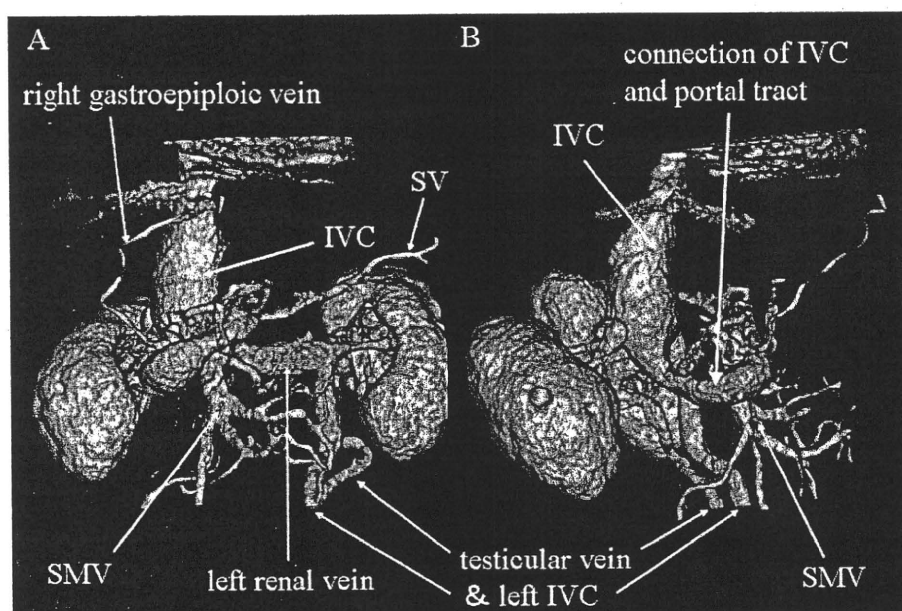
Three-dimensional computed tomography of the venous system. The inferior vena cava (IVC) communicated with the superior mesenteric vein (SMV) and the splenic vein (SV). The IVC disappeared below the level of its connection with the SMV and SV. Two veins, apparently a left IVC and the testicular vein, flowed into the left renal vein. A: Anterior view. B: Right lateral view. IVC: the inferior vena cava, SMV: the superior mesenteric vein, SV: the splenic vein.
